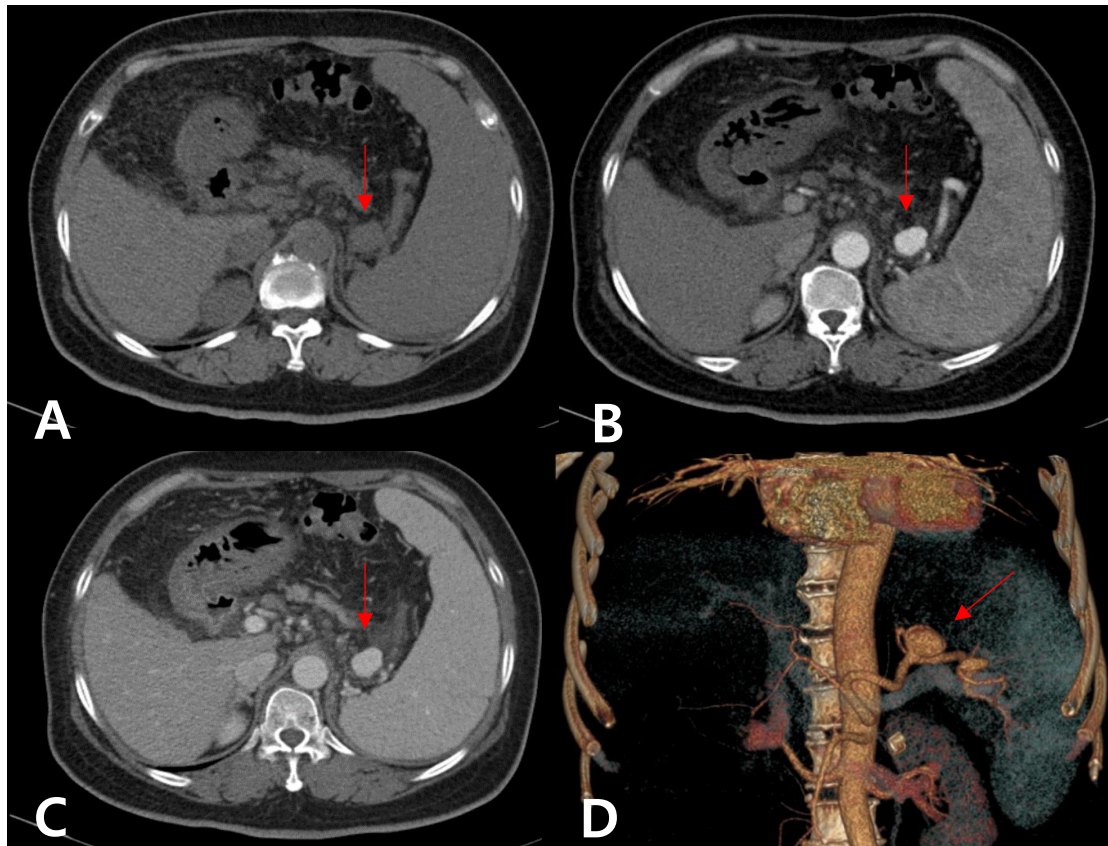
2.2cm diameter Splenic artery aneurysm (arrow) on dynamic CT. (A; pre enhancement phase, B: arterial phase, C: portal phase, D: 3D reconstruction processed image)
